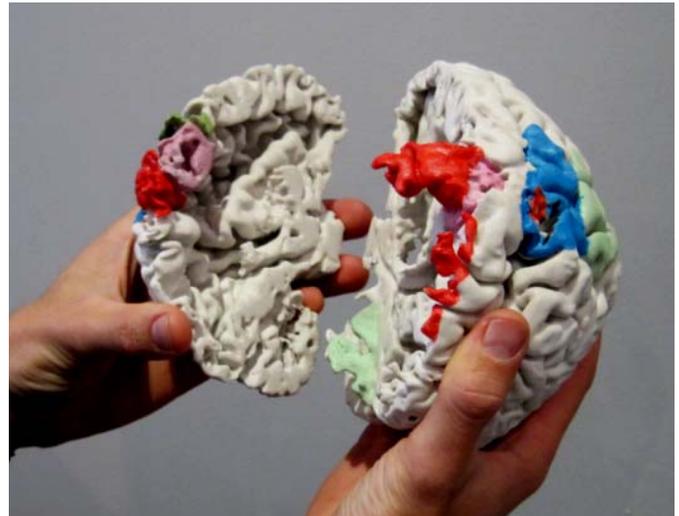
Rapid prototype model showing both structural and functional MRI features relative to a tumour. The tumour is shown in pink. Regions of activation identified using functional MRI are as follows: red – right hand; blue – left hand; green – left foot.
